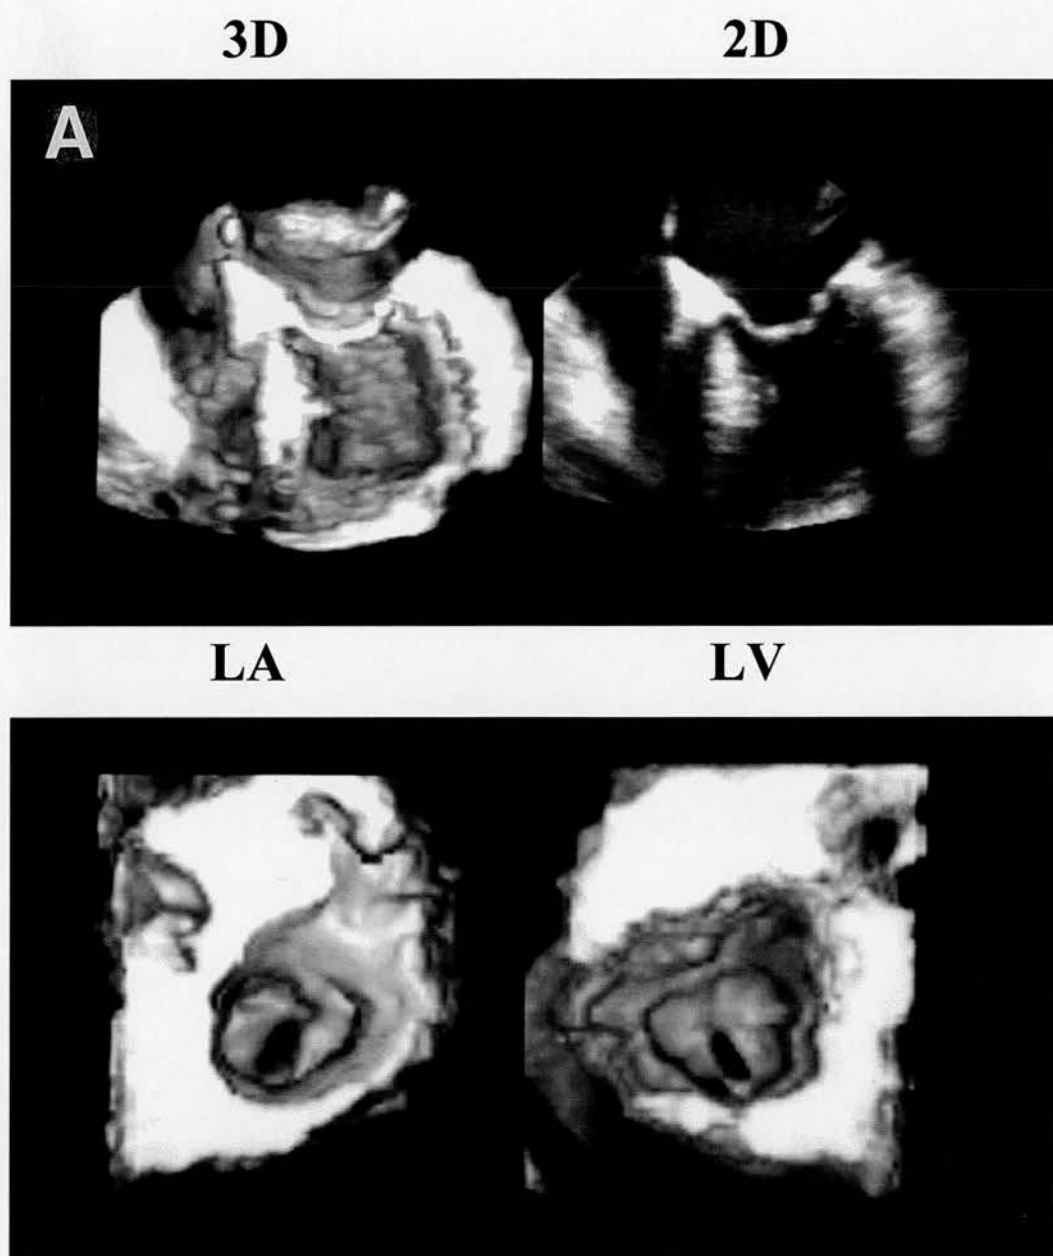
Examples of transoesophageal three-dimensional (3D) reconstruction of a stenotic mitral valve. (A), top - long-axis view with the corresponding two-dimensional (2D) image on the right hand side; bottom - reconstruction of the mitral valve *en face*, corresponding left atrial - (LA) and left-ventricular perspective (LV). Small central orifice with well visualized outline of the extent of commissural fusion from both perspectives.
